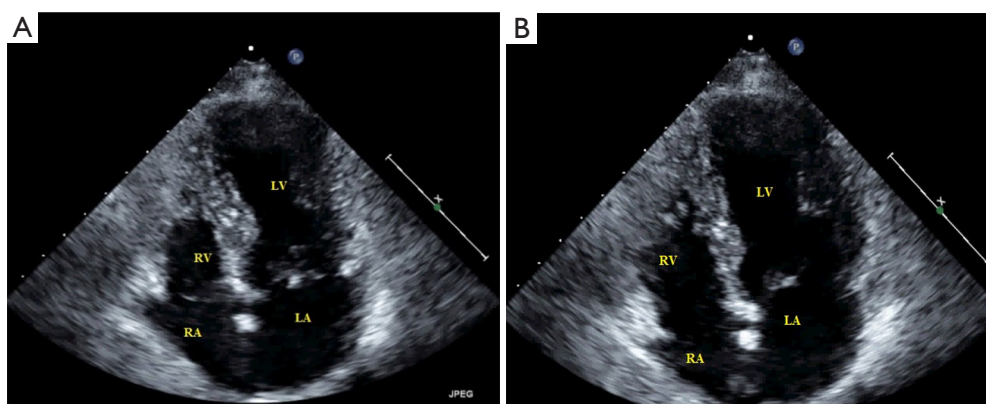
2D echocardiography showed dilated LV and akinesia of LV apical segments. LV, left ventricle.
